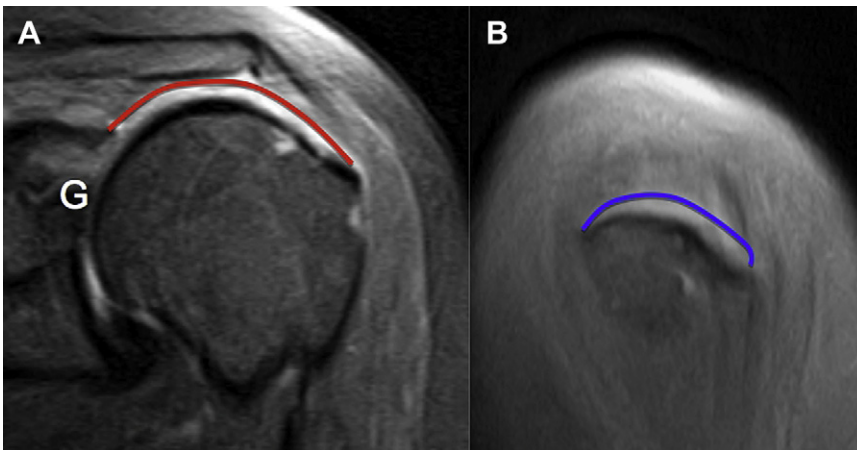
Massive tear. Coronal (A) and sagittal (B) fat-suppressed T2-weighted images of the left shoulder demonstrate a massive, retracted cuff tear with long longitudinal (*red line*) and wide transverse components (*blue line*). The tendon fibers are retracted to the level of the glenoid (G), and the greater tuberosity facets are bare.
